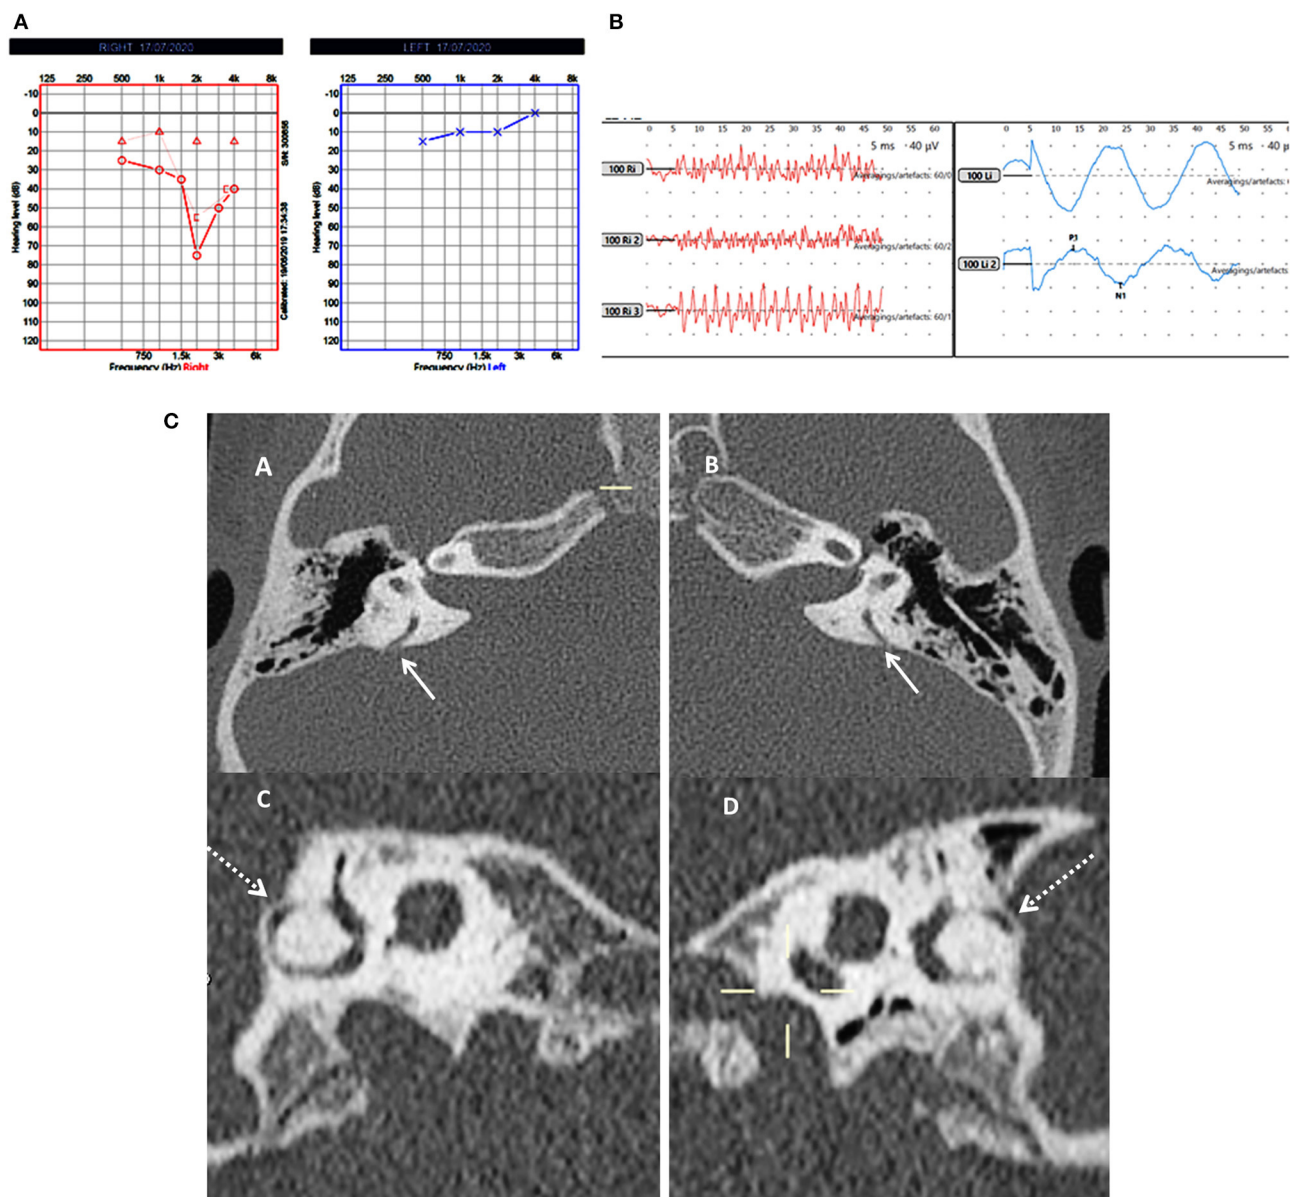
Case number 5—Bilateral posterior semicircular canal thinning. (A), Pure tone audiometry showing right mixed hearing loss. (B), cVEMP showing absent response on the right and normal amplitude on the left; in this child vHIT was normal and there were no symptoms of balance problems. (C)—CT scan images of the right (A) and left (B) petrous temporal bone in the axial plane demonstrates apparent dehiscence of the posterior semi-circular canal (white arrows). Sagittal oblique reconstruction of the right (C) and left (D) petrous temporal bone parallel to the plane of the posterior semi-circular canal demonstrates thinning of the overlying bone (dotted arrows) measuring 0.5 mm in thickness on both sides.
